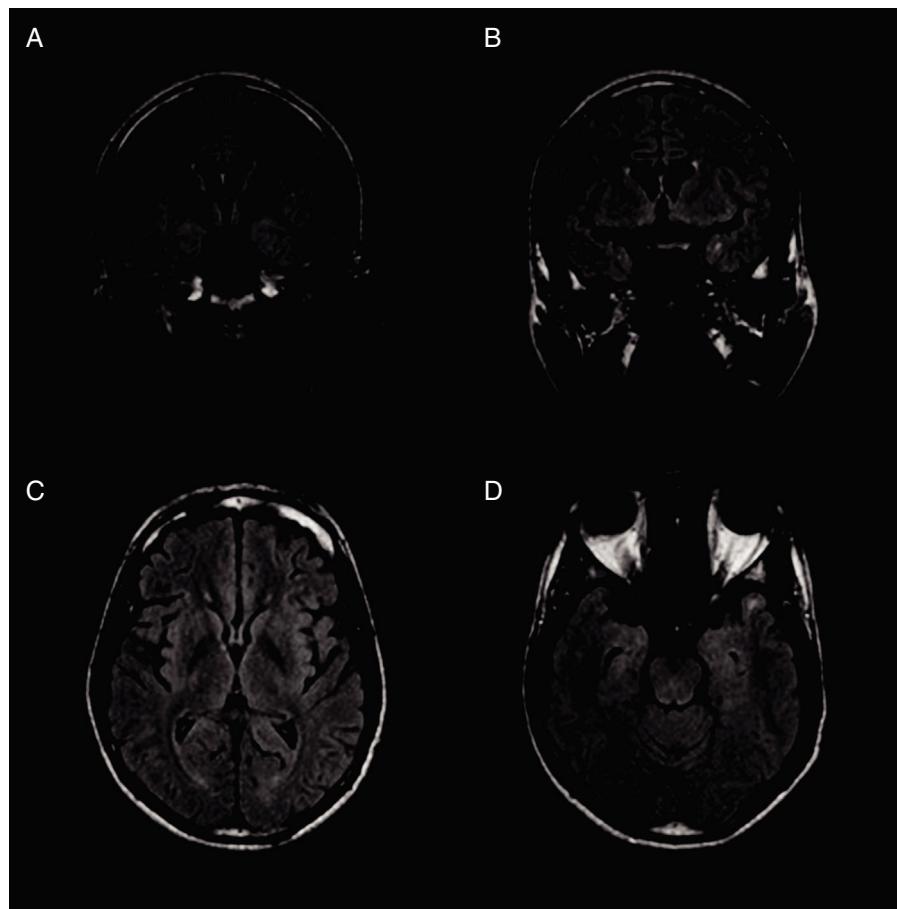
Follow-up MRI scan performed 12 months after antibiotic treatment completion, showing improved parenchymal involvement. Mild hyperintensity persisted in the temporal and perisylvian regions on axial (A and B) and coronal FLAIR (C and D) sequences.
